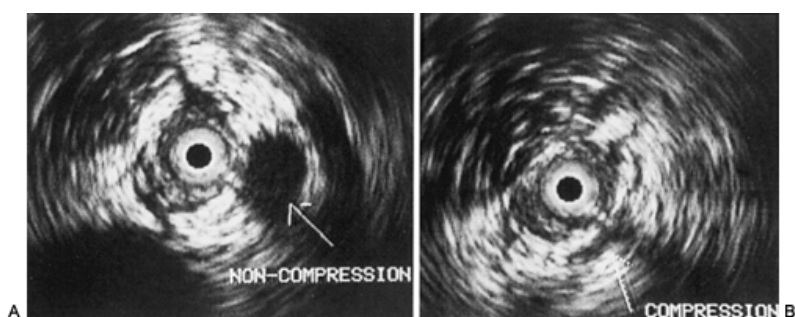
A: An endoluminal ultrasound study performed at the level of the ureteropelvic junction (UPJ) reveals a large vessel crossing the UPJ directly posterior (*arrow*). Noncompression refers to the conditions at the time of scanning: no manual pressure was put over the kidney area. B: By pressing down on the flank directly overlying the area of the scanning, the crossing vessel (*arrow*) can be compressed, thereby indicating its probably venous nature.
